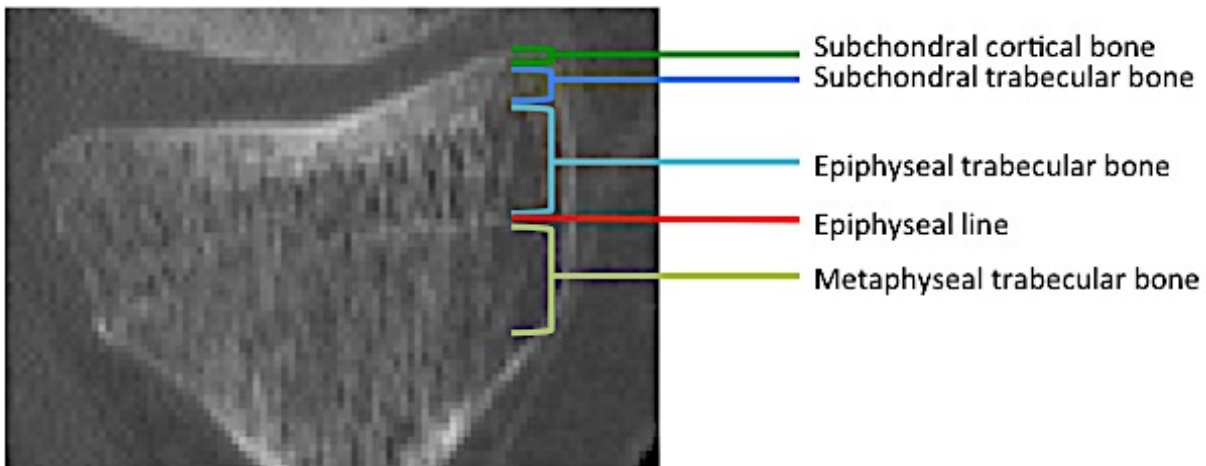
Computed tomography (CT) image in the sagittal plane of the proximal tibia including subchondral cortical bone, subchondral trabecular bone, epiphyseal line (epiphyseal scar)⁴¹, epiphyseal trabecular bone, and metaphyseal trabecular bone.
